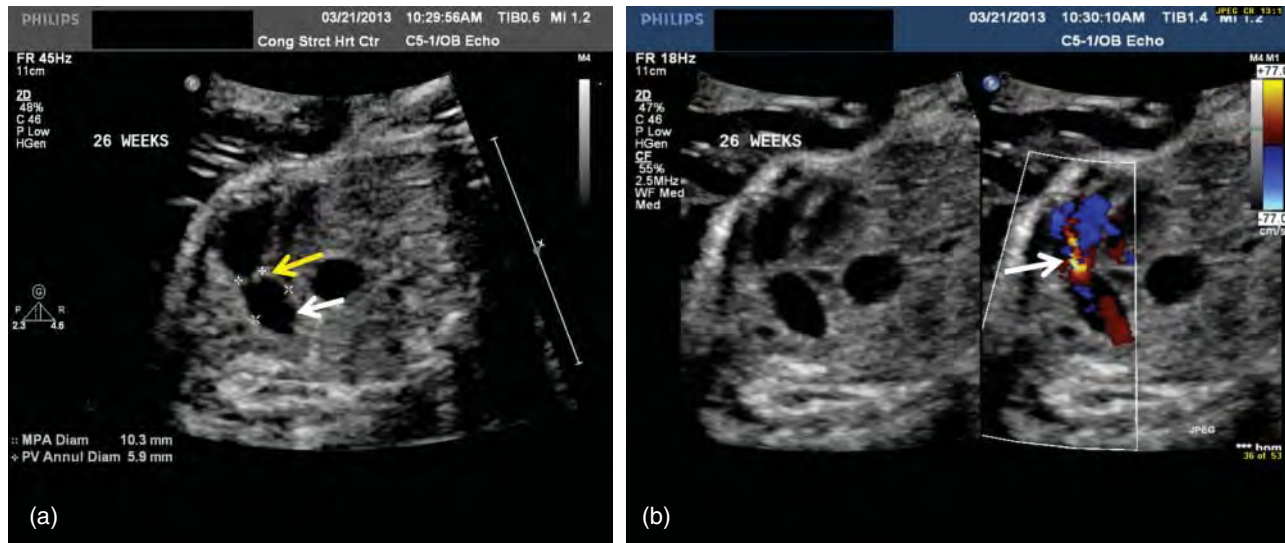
Fetal echocardiogram images of a fetus at 26 weeks' gestation with absent pulmonary valve and muscular ventricular septal defect (VSD; not associated with TOF). This patient also had cardiac dextroposition secondary to left-sided diaphragmatic hernia. Patient was placed on extracorporeal membrane oxygenation (ECMO) at birth and diaphragmatic hernia was subsequently repaired. Patient expired after 11 days on ECMO support secondary to poorly developed lung parenchyma bilaterally. (a) 2D image showing the dysplastic pulmonary valve (yellow arrow) and dilated main pulmonary artery (white arrow). (b) This 2D and color image shows pulmonary regurgitation (white arrow).
